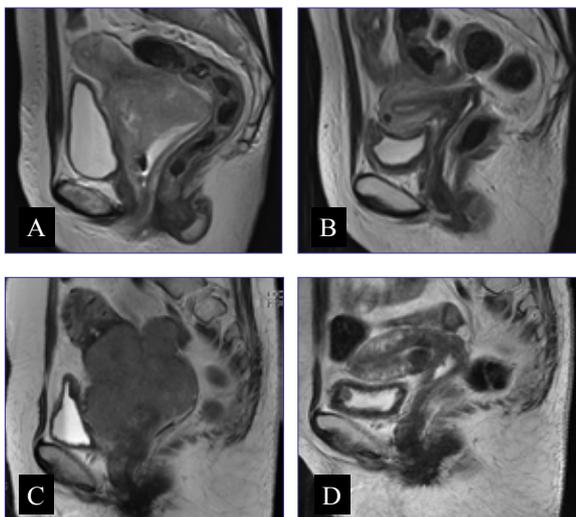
(A) case 1: Sagittal T2-weighted magnetic resonance image reveals an 6-cm cervical tumor. (B) case 1: Follow-up magnetic resonance image confirms disappearance of the cervical tumor after CCRT. (C) case 2: Sagittal T2-weighted magnetic resonance image reveals an 8-cm cervical tumor. (D) case 2: Follow-up magnetic resonance image confirms disappearance of the cervical tumor after CCRT.
